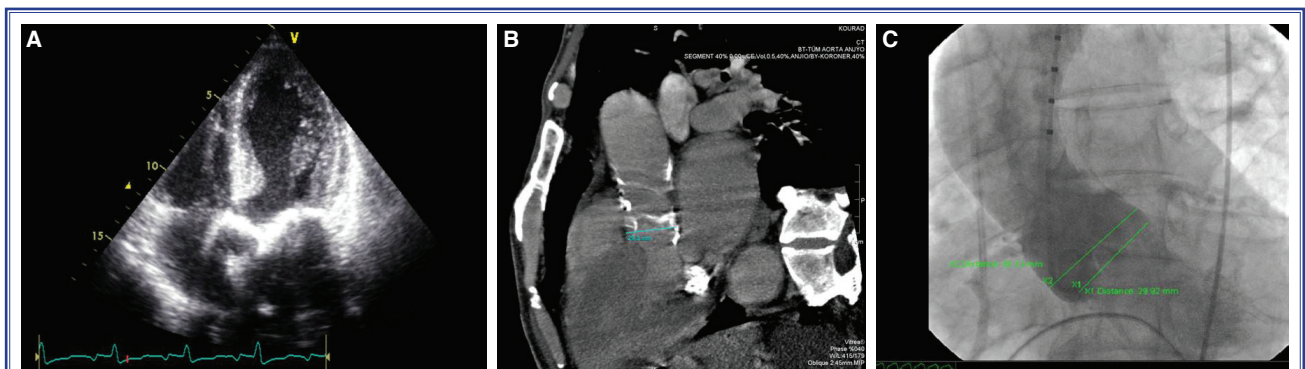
(A) Transthoracic echocardiography, sigmoid septum and severe mitral annular calcification (Four-chamber view). (B) CT angiography, Measurement of aortic annulus diameter. (C) Aortography under rapid pacing, Measurements of aortic annulus diameter and sinus Valsalva width.
